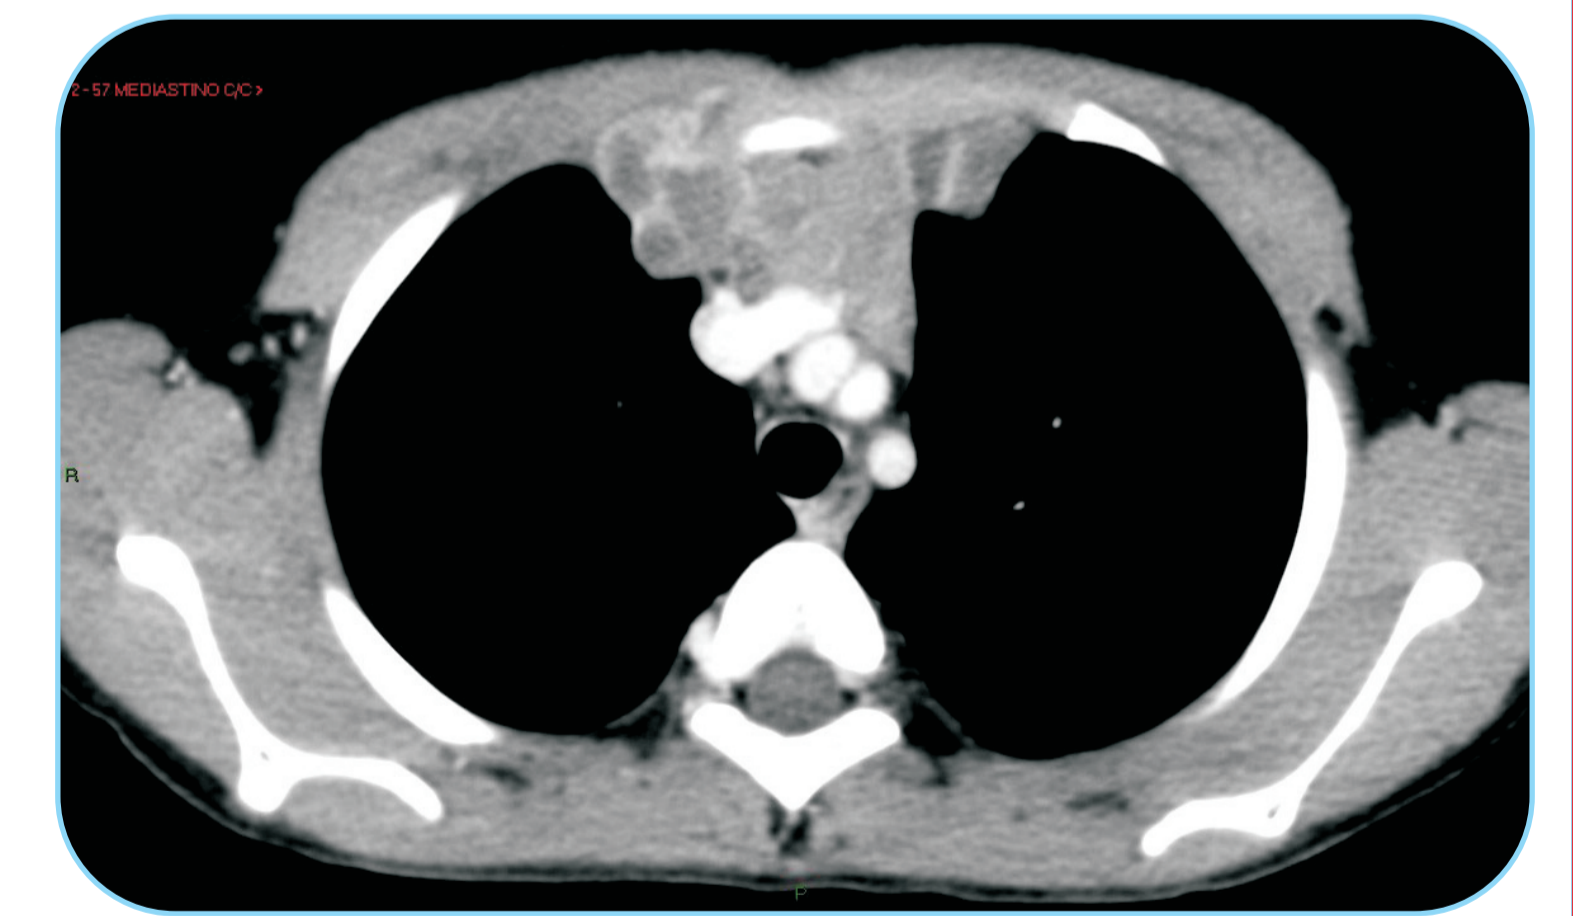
CT thorax. August, 2016
